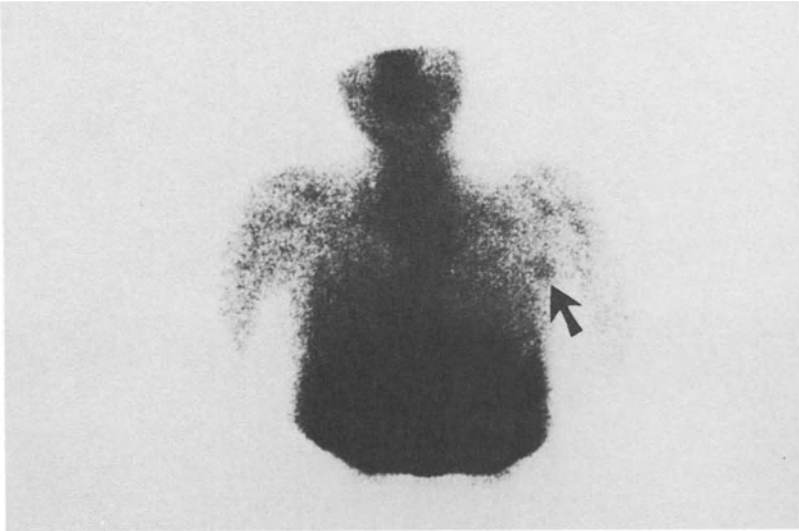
reports an example of scintigraphic confirmation of a clinically suspected left axillary lymphatic metastasis. A primary melanoma had been
